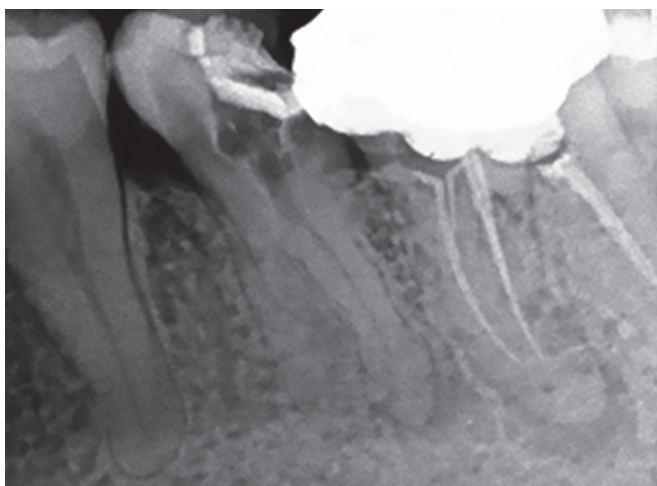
Preoperative diagnostic radiograph of tooth #35
